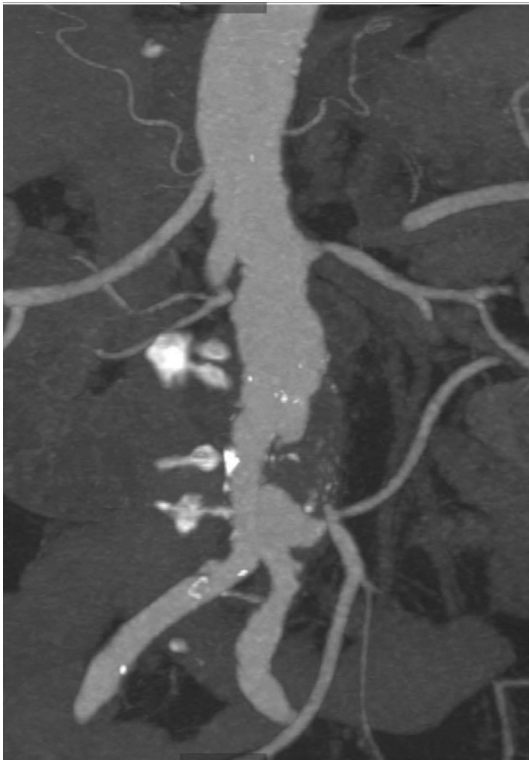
CTA showing significant long infrarenal aortic stenosis.
